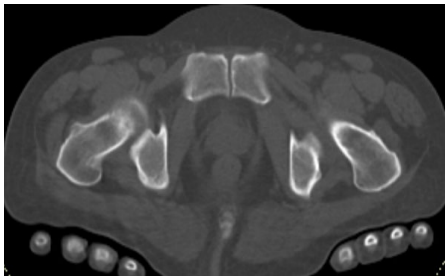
a, b, c, d. No evidence of lytic lesions on the left CT image in the sacro-iliac bones (a), lumbar vertebra (b), ischium-pubic bones (c) and bilateral femoral diaphysis (d).
